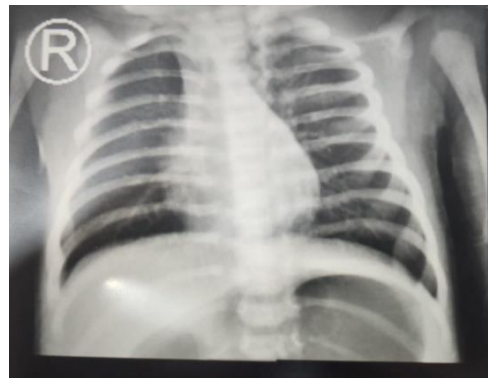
Chest radiograph showing infiltrates (indicated by arrows) in the left peripheral lung area suggestive of bronchopneumonia
